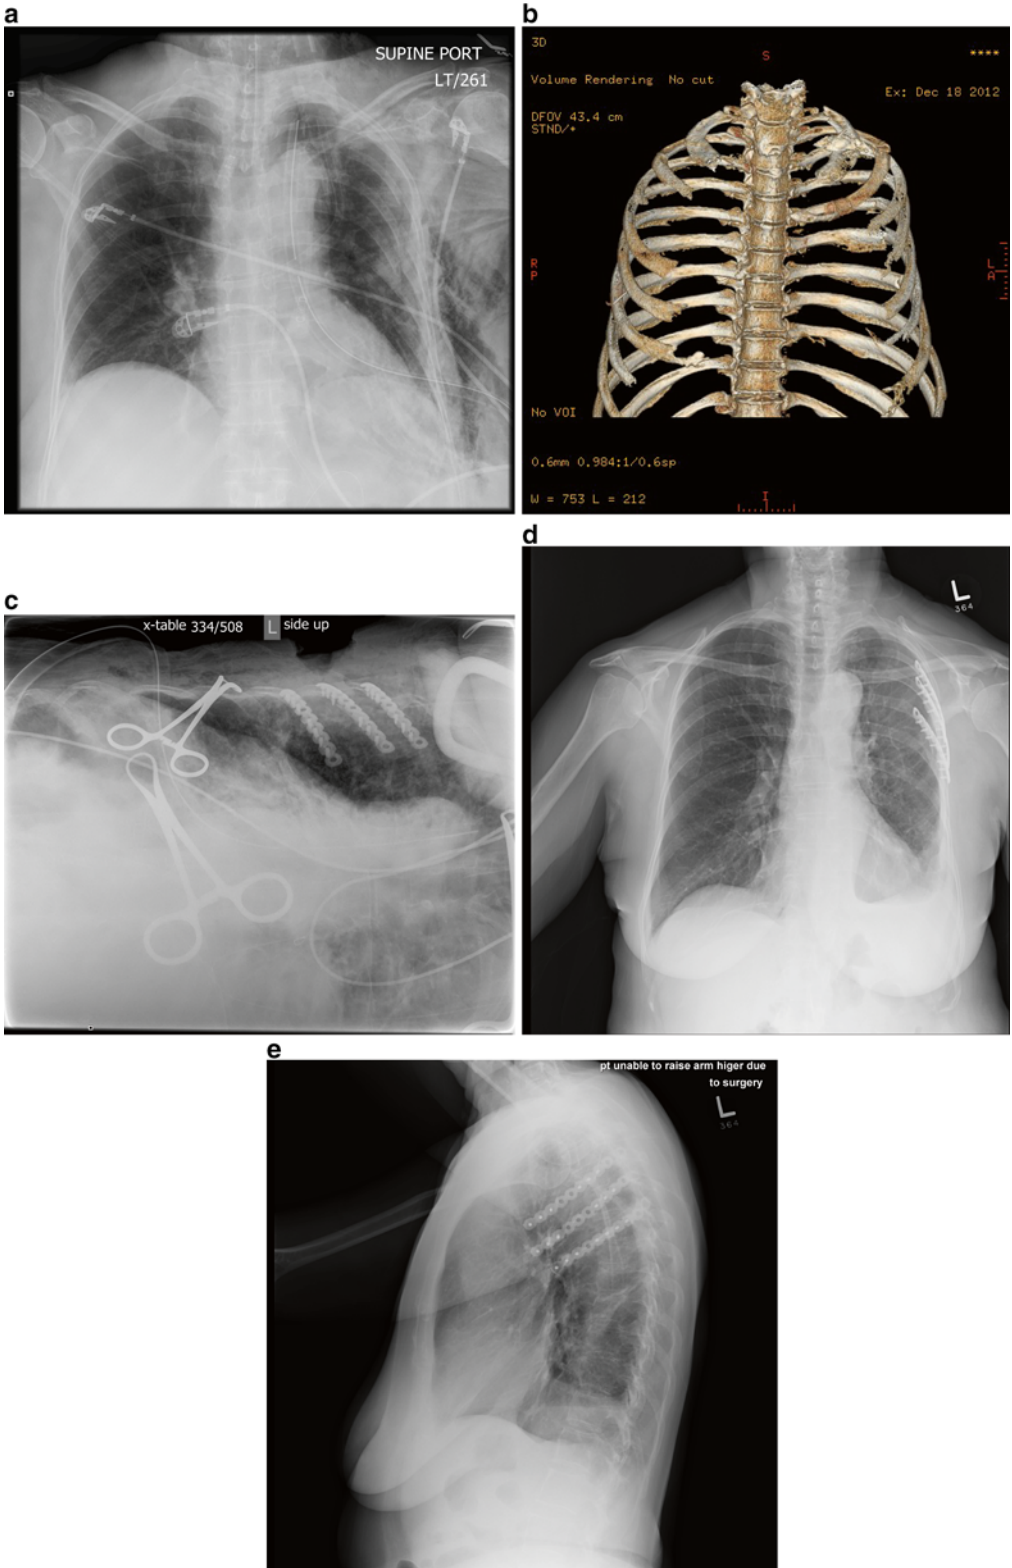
A 65-year-old female sustained multiple rib fractures in a motor vehicle collision demonstrated on chest radiographs (a) and a 3D CT scan (b). She was intubated and ventilated, but it was not possible to wean her from mechanical ventilation. Fixation of the flail segment
